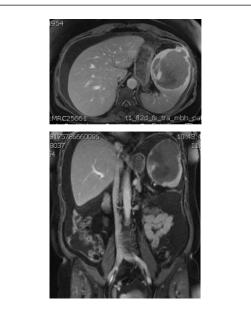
T1-weighted MRI scan, revealing a large splenic lesion with hypo- and hyperintense areas
